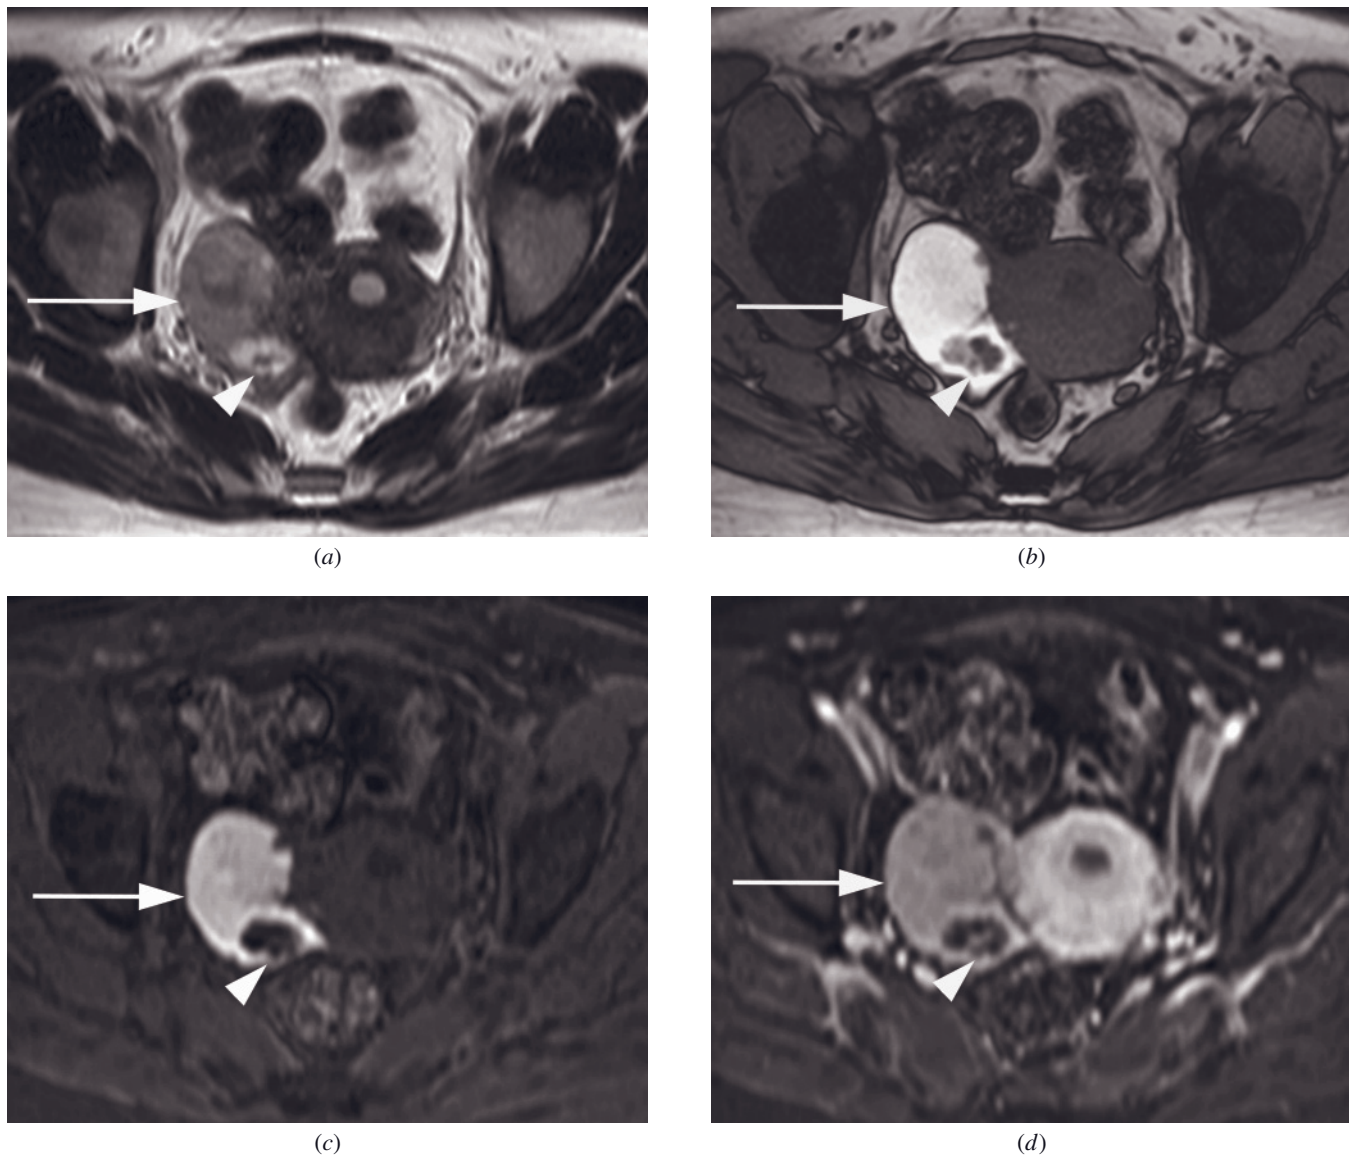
Clear cell carcinoma with hemorrhage. Transverse T2-weighted ETSE (*a*) and out-of-phase (*b*), fat-suppressed (*c*), and gadolinium-enhanced fat-suppressed (*d*) T1-weighted gradient echo images show a right ovarian mass (arrow) with signal intensity consistent with hemorrhage and a small nodular component (arrowhead). A small amount of enhancement is seen, although difficult to appreciate in a background of high-signal-intensity blood products because of dynamic range effects. Pathologic evaluation revealed clear cell carcinoma with no evidence of endometriosis.
